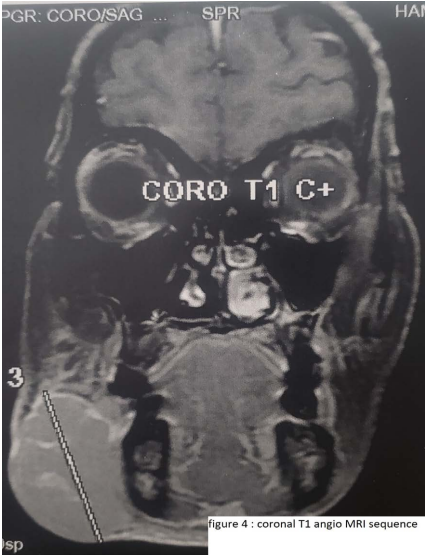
Coronal T1 angio MRI sequence.
